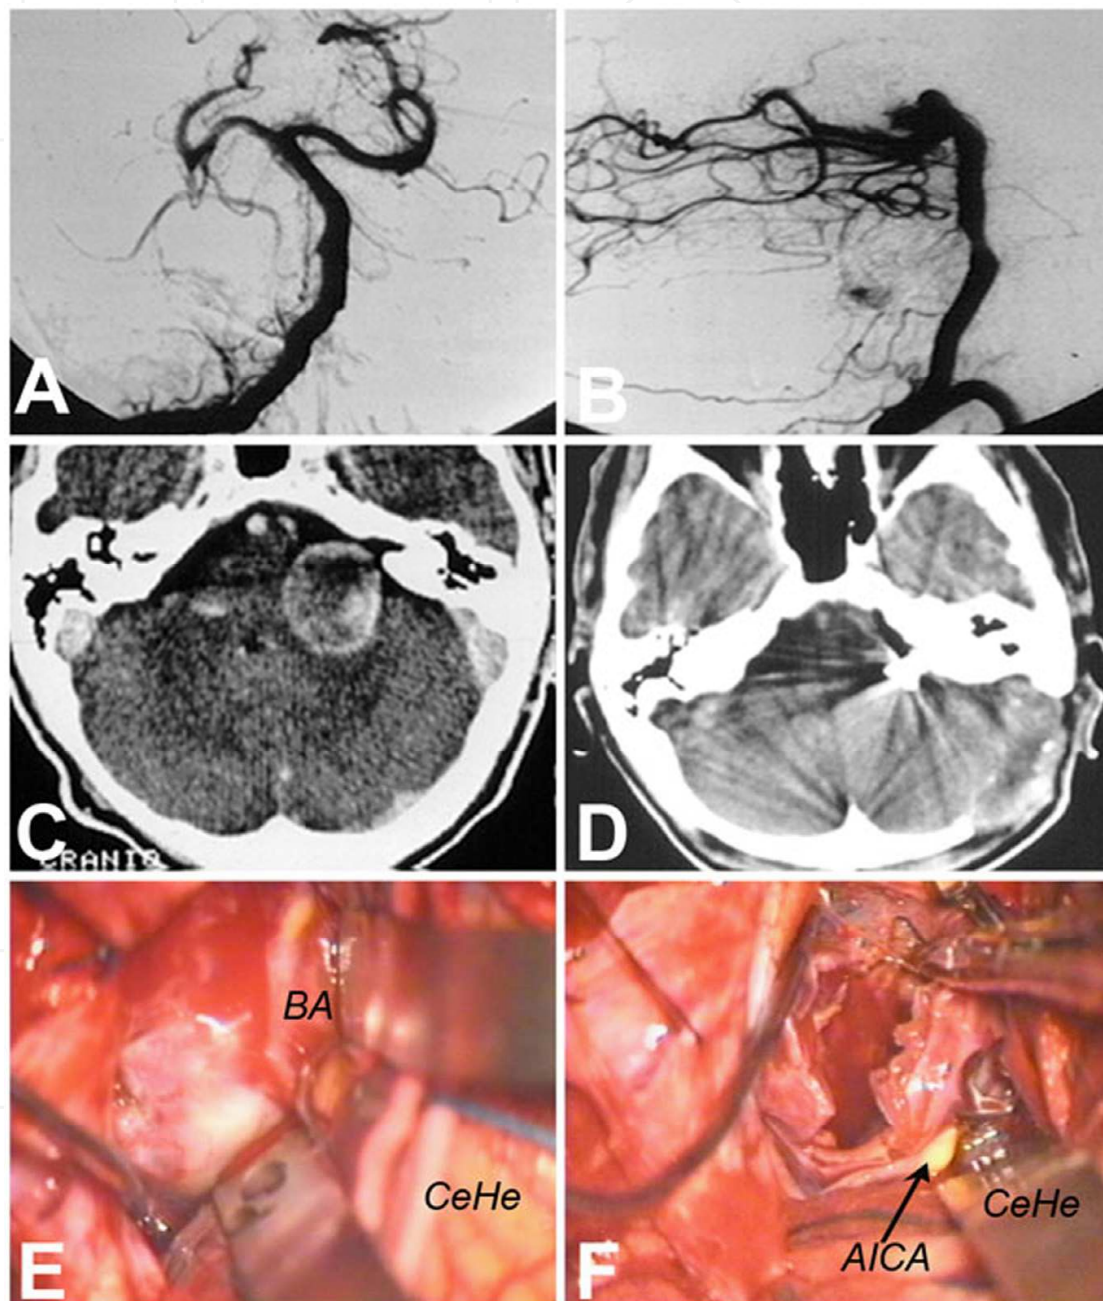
Preoperative angiography(A,B), preoperative and postoperative CT scan (C,D) and intraoperative images of a giant thrombosed aneurysm of the AICA after its origin from the basilar artery (BA), which was clipped and opened through a left retrosigmoid approach. The aneurysm mimicked, clinically, a vestibular schwannoma and its exposure required a certain degree of retraction of the left cerebellar hemisphere (CeHe).
